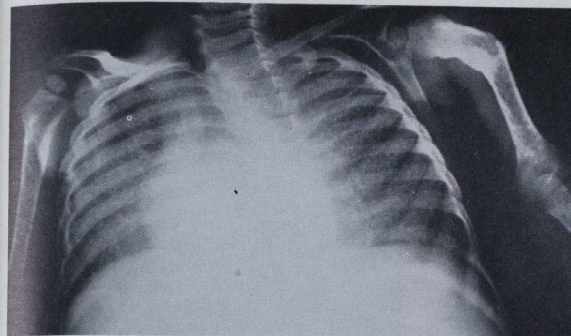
Chest X-ray showing diffuse miliary mottling due to pulmonary infiltration with Gaucher cells, and mal-union of a pathological fracture of the left humerus.
